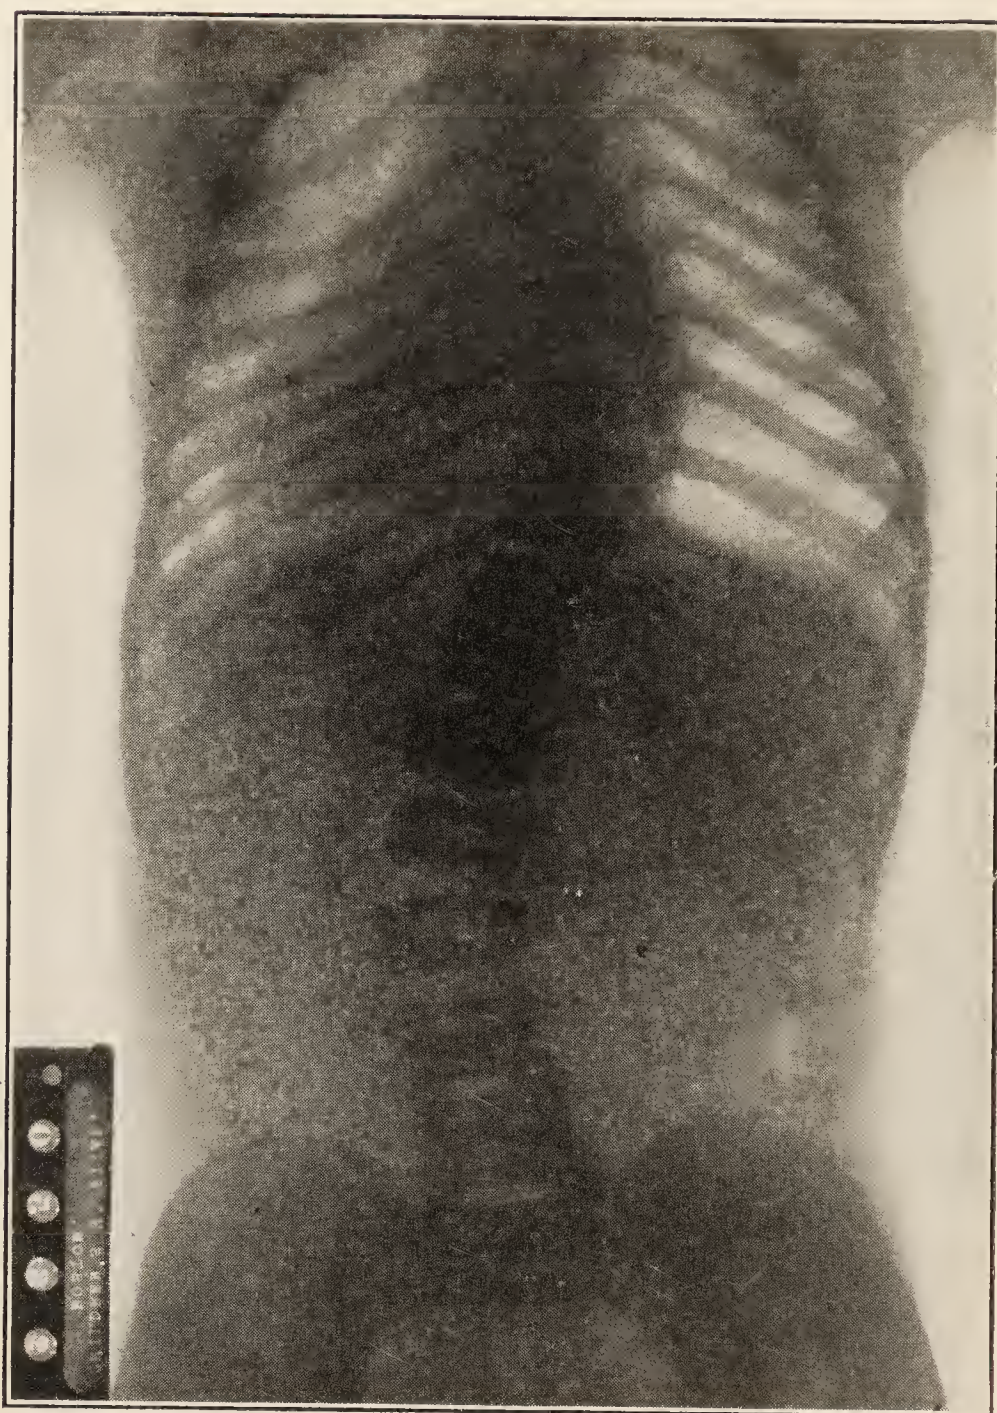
X-ray of patient shown in Fig. 64. Before treatment.
